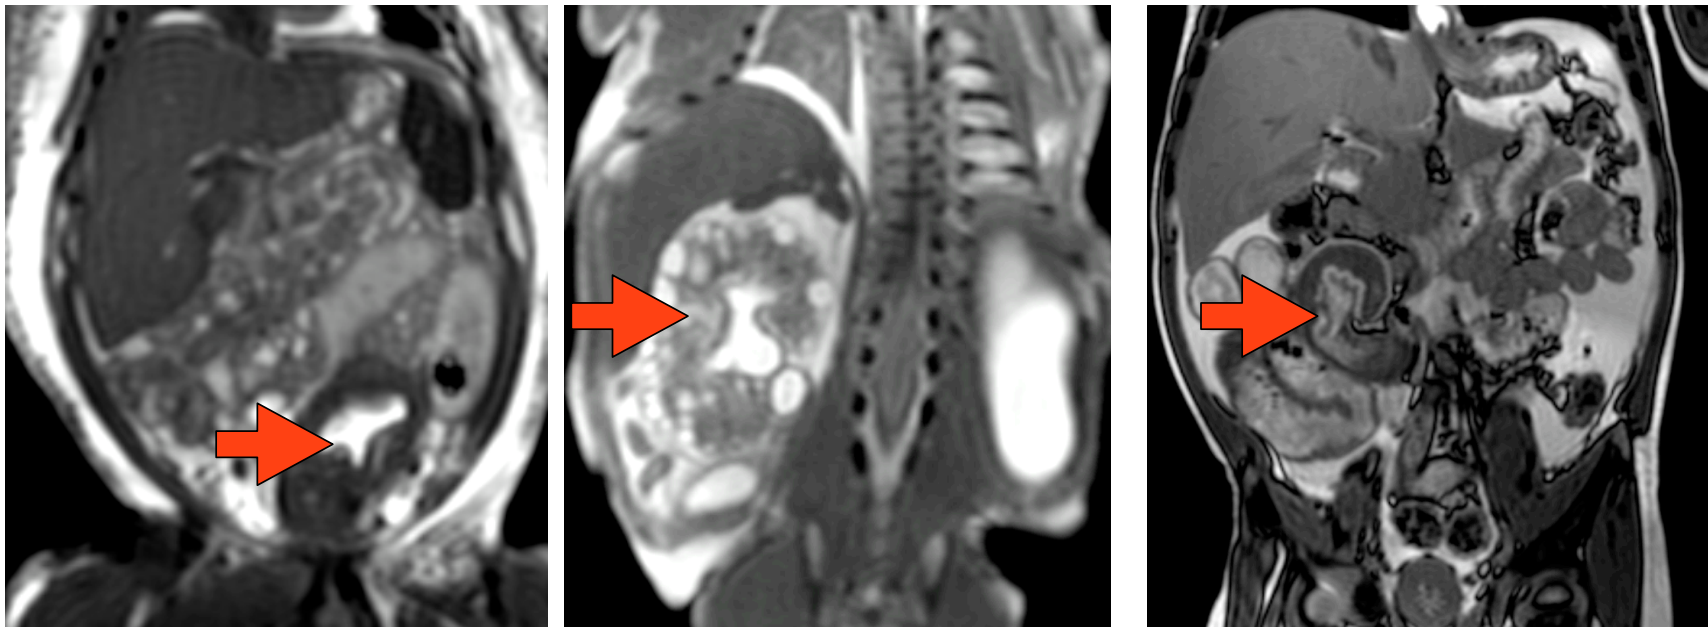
Abdominal pathology on post-mortem MR imaging
